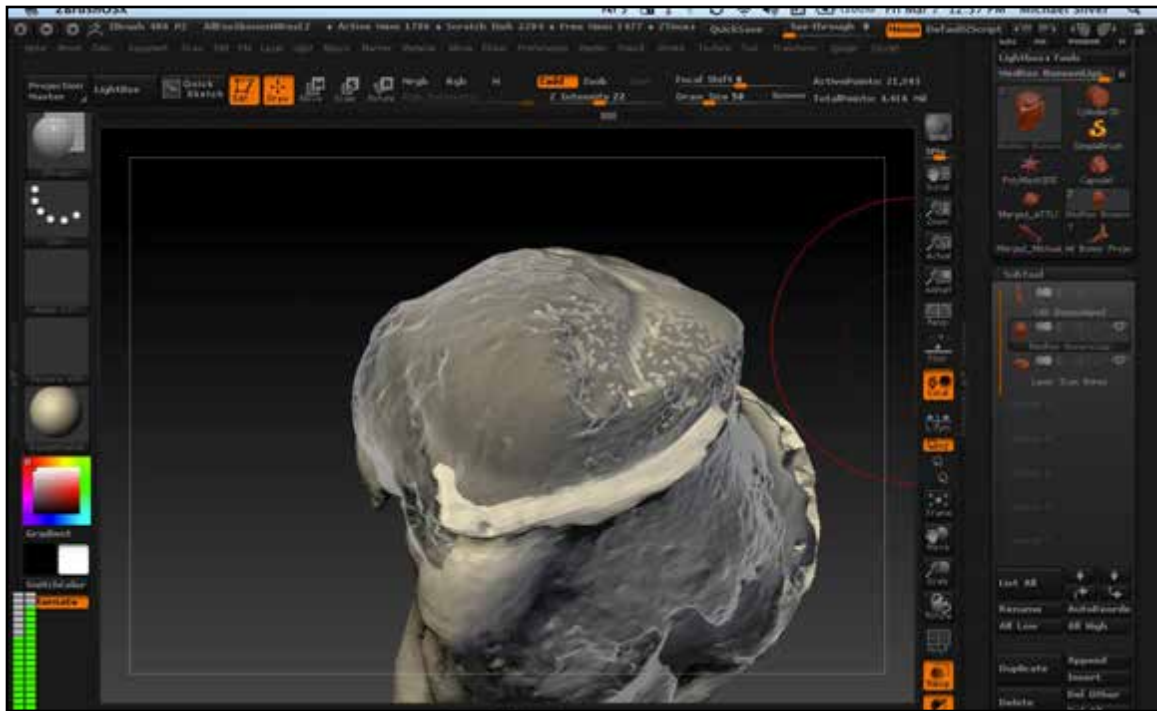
Using ZProject brush to repair incomplete area of CT based mesh using laser scan mesh.
